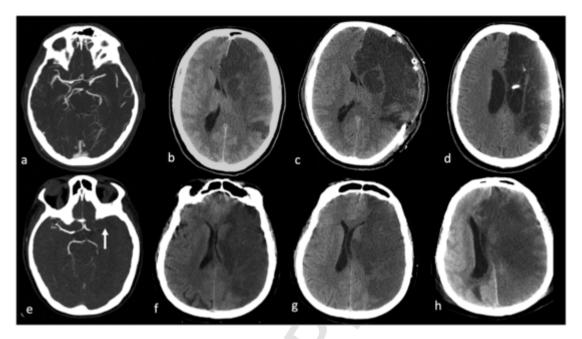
Brain CT follow-up in two representative patients with mMCA. Enhanced CT (Panels a-e); un-enhanced CT (Panels b-c-d-f-g-h). Patient with mMCA stroke underwent DHC (upper panels).CT performed at 24 h: left fronto-parieto-temporal stroke with cortical swelling, shift of midline structures and mass effect on the ventricular system (Panel b). Note occlusion of left mMCA (Panel a). CT performed at 48 h: right fronto-temporo-parietal craniectomy, increased parenchymal swelling with parenchymal herniation through the craniotomy operculum; the shift of the structures of the midline is unchanged (Panel c).CT performed at 4 months: craniotomy operculum repositioned and evolution of mMCA stroke in the gliotic-malacic stage with passive dilation of the ventricular system and cortical necrosis (Panel d).Patient with mMCA under BMT (lower panels).CT performed at 24 h: left fronto-parieto-temporal stroke with cortical swelling, midline structures shift and mass effect on the ventricular system (Panel f). Note occlusion of left mMCA (Panel e).CT performed at 48 h: increased parenchymal swelling and shift of the midline structures (Panel g).CT performed at 5 days: Further increase of parenchymal swelling with subfalcine herniation and increased midline structures shift and mass effect on the ventricular system (Panel h); the patient died 1 day later.
